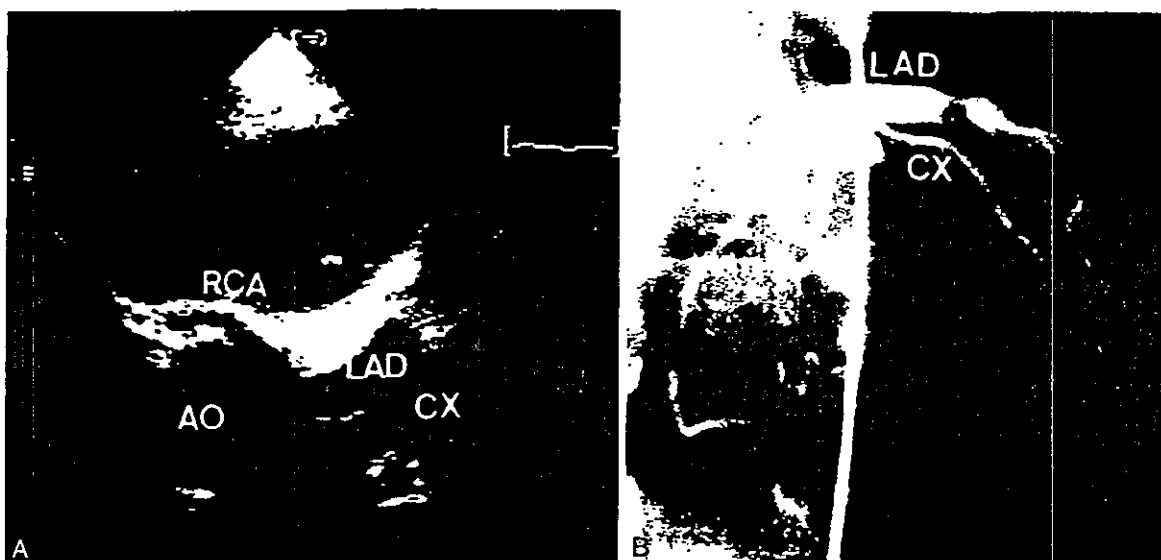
(A) Echocardiograph of the left coronary artery shows a moderate-sized aneurysm (5 mm) of the left anterior descending coronary artery. The right coronary artery arises from the left main trunk and courses between the aorta and the right ventricular outflow tract. (B) Selective left coronary angiography reveals two aneurysms at segments 6 and 7. The right coronary artery arises from the left main trunk. AO, aorta; CX, left circumflex coronary artery; LAD, left anterior descending coronary artery; RCA, right coronary artery.
